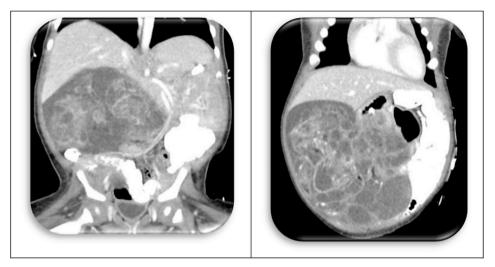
CT scan of Gastric Teratoma.
